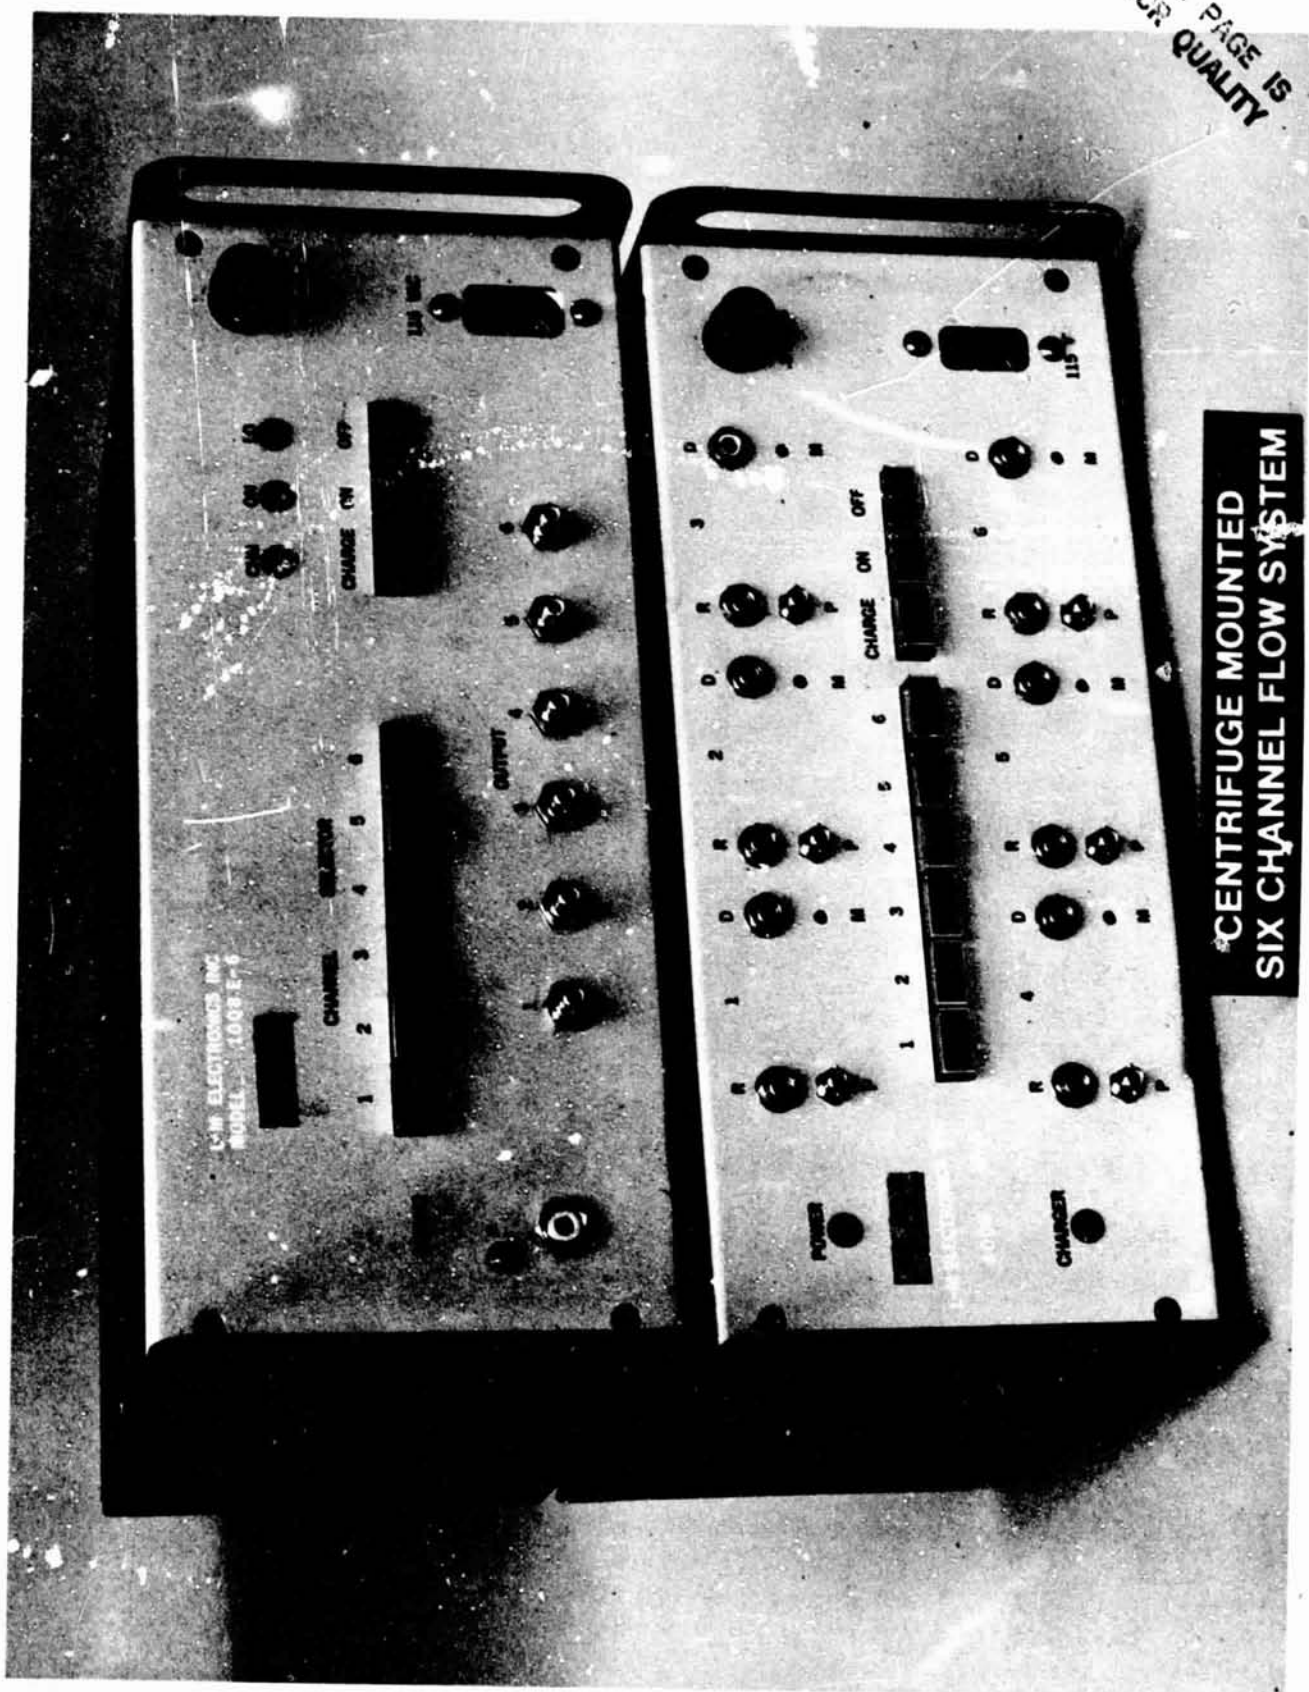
Ames six channel wireless telemetry Doppler flowmeter.
